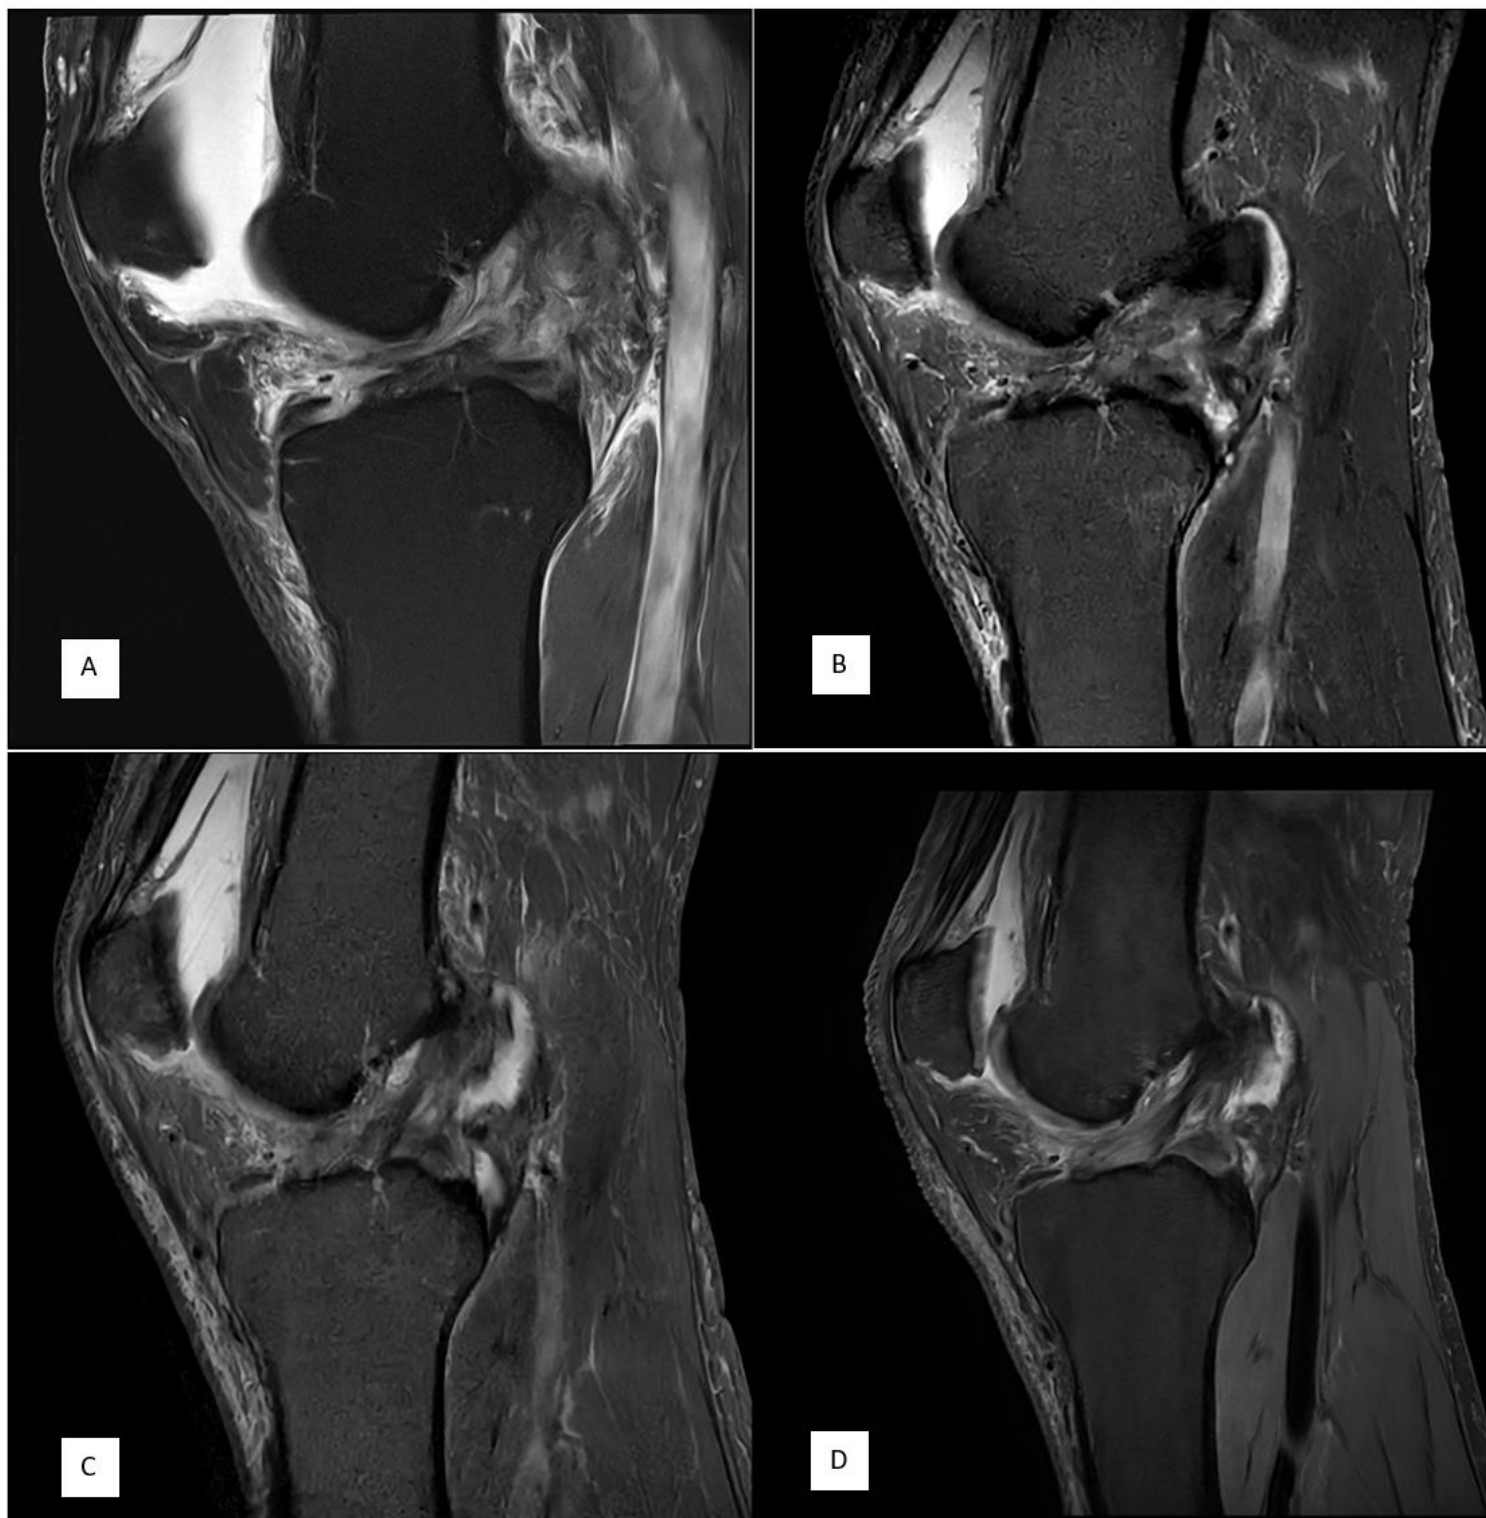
Serial sagittal MRI of the left anterior cruciate ligament from acute rupture to delayed re-continuity. (A) MRI performed one day post-injury demonstrates complete ACL rupture with loss of normal fibre continuity; (B) MRI performed approximately 6 weeks post-injury, immediately before PRP treatment commenced, demonstrates persistent severe ACL abnormality without mature ligamentous re-continuity; (C) MRI performed 14 weeks post-injury, after five PRP treatments, demonstrates improved fibre organisation and apparent re-continuity along the expected ACL course; (D) High-resolution sagittal 3D proton-density fat-suppressed MRI performed 50 weeks post-injury demonstrates further maturation of a continuous ACL-like low-signal structure.
